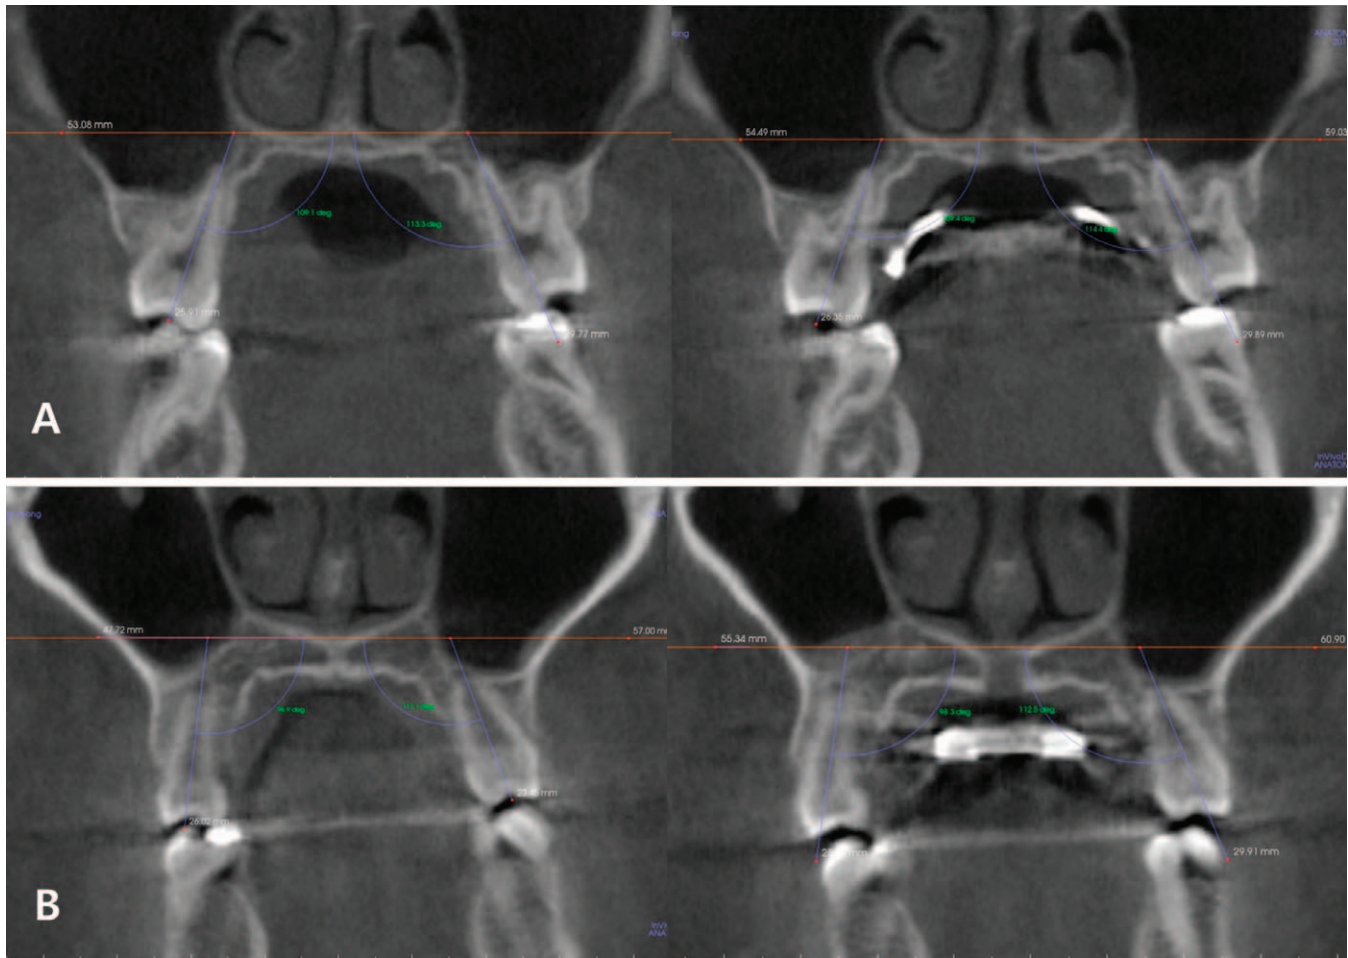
Images of cone-beam computed tomograms taken before and after the bone-borne maxillary expansion. Palatal suture was separated and expanded with minimal tipping of the teeth and the alveolar bone. The added lines were used for measuring the inclination of the teeth (nasal floor and axis of the palatal root). (A) At the upper first molar. (B) At the upper second premolar (left, before expansion; right, after expansion).
